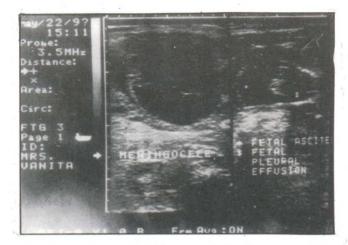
Sonogram showing large meningocele, fetal ascitis and pleural effusion.
